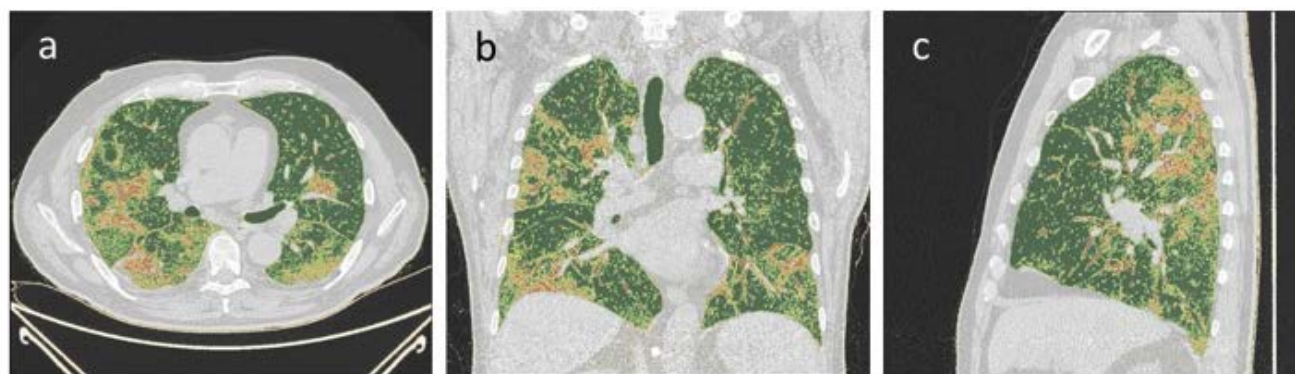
CT scan of a 45-year-old man analyzed with 3D slicer. a) The axial thin-section scan shows ground-glass opacities highlighted in yellow by the operator. Then, the program calculates the volume of the healthy lung parenchyma, the percentage of lung parenchyma occupied by the ground-glass opacities, and the percentage of consolidation. b,c) Coronal and sagittal thin-section scan, red areas indicate consolidation.
